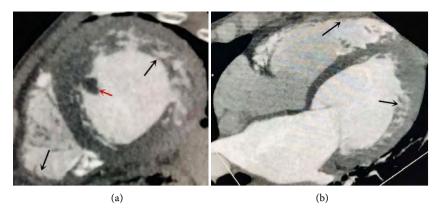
Retrospective coronary computed tomography angiography showed massive thrombus formation (red arrow) and non-compacted myocardium (black arrows) in left ventricle (a); Numerous prominent trabeculations and deep intertrabecular recesses (arrows) in left and right ventricle (b).
